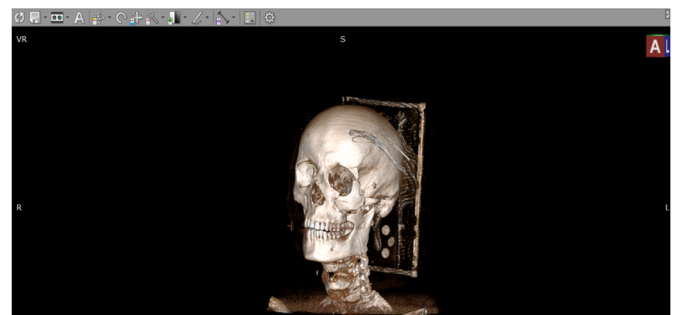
Preoperative CT scans in DICOM (digital imaging and communications in medicine) format displayed via RadiAnt DICOM Viewer software (64-bit).
